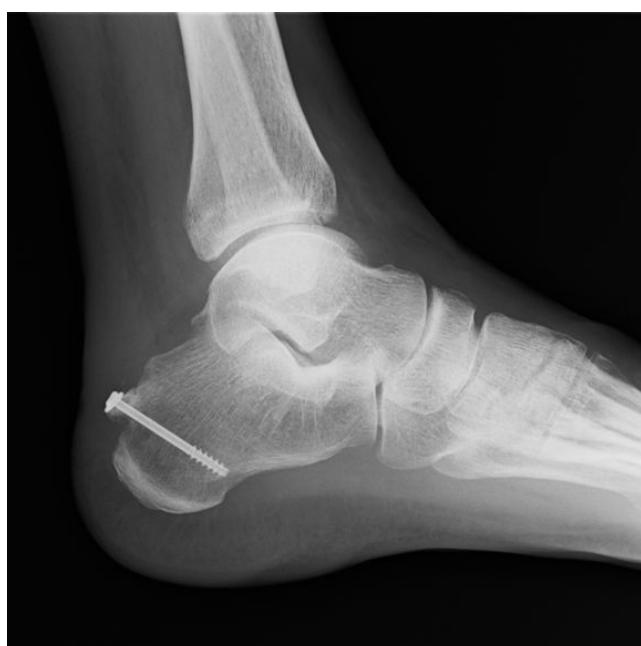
Plain radiograph after two months.
